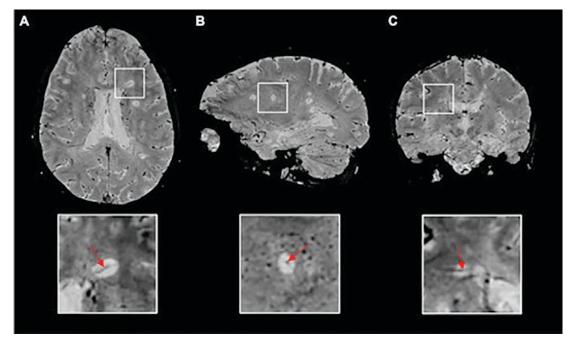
Central vein sign observed on a 3T MRI scan in axial, sagittal, and coronal planes in a patient with RRMS Source: https://pmc.ncbi.nlm.nih.gov/articles/PMC9971159/figure/Fig1/
